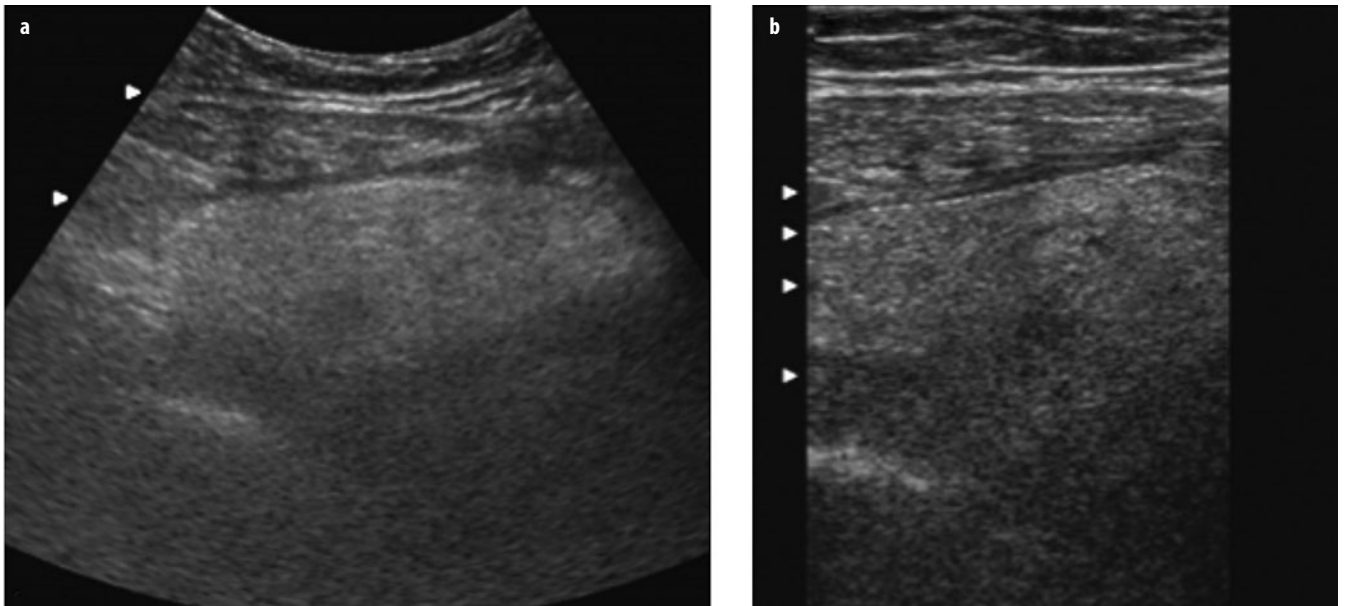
a, b. Ultrasound (US) images of the right lower quadrant in an 11-year-old girl with right lower quadrant pain show an ill-defined, hyperechoic mass consistent with an omental infarct
